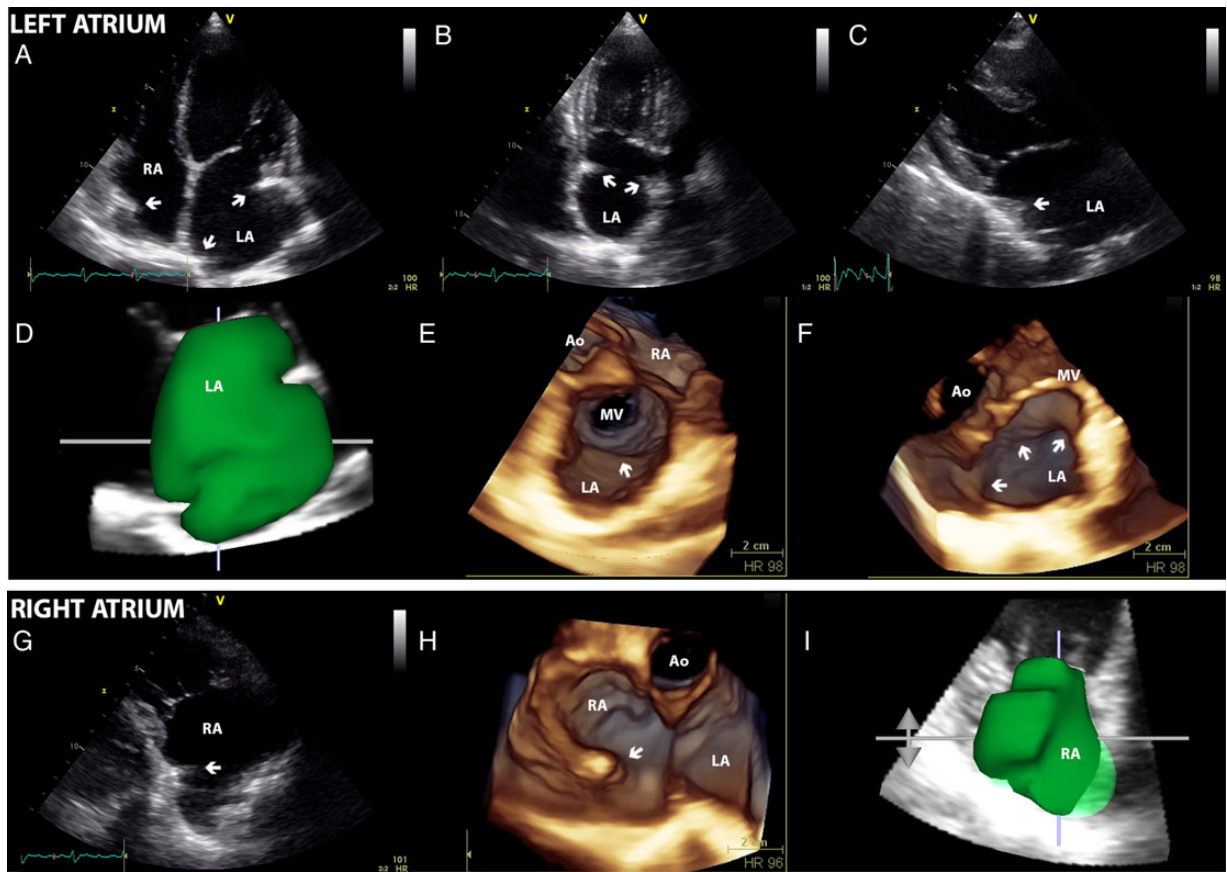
Two- and three-dimensional echocardiography acquisitions in a patient who underwent heart transplant using the standard technique. Both the left and right atria are grossly enlarged and the atrial sutures (arrows) are visualized giving the left atrium the typical ‘snowman’ shape. Arrow, suture lines, Ao, aorta, LA, left atrium; LV, left ventricle; MV, mitral valve; RA, right atrium.
